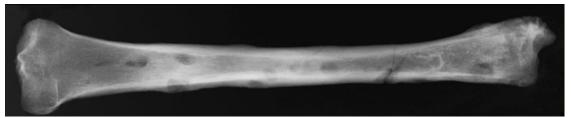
i. - x-ray of CR86.45- Note endosteal involvement, extensive periosteal remodeling
